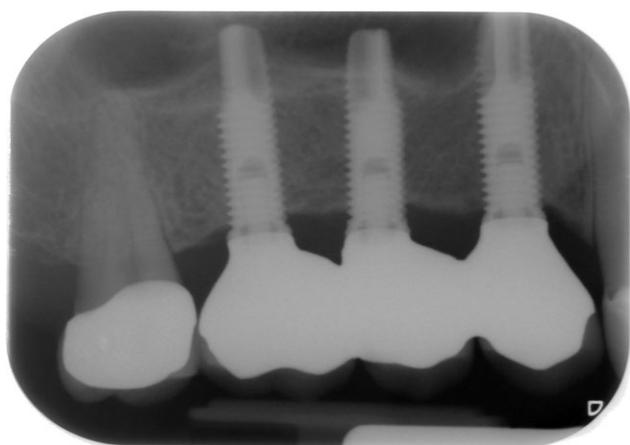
Intraoral X-ray performed after 2 years of loading.
